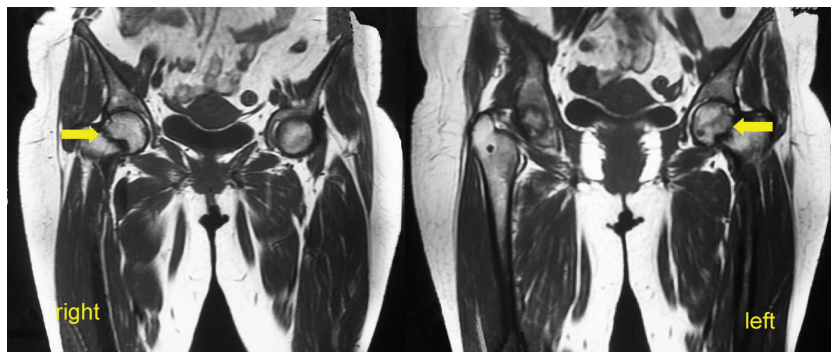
Pre-operative pelvic MRI of the second case. Arrows show the fracture line.
